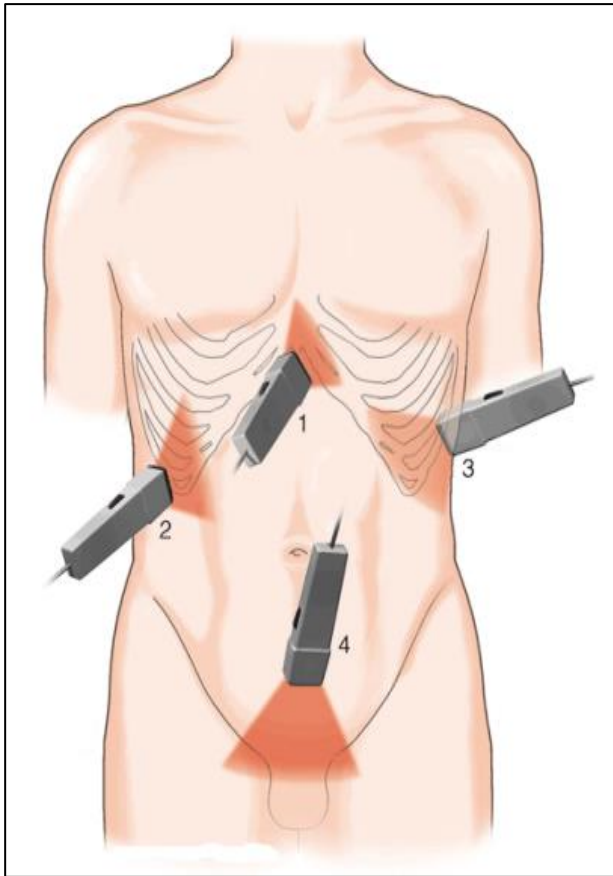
Fast (focused assessment for sonography in trauma).
